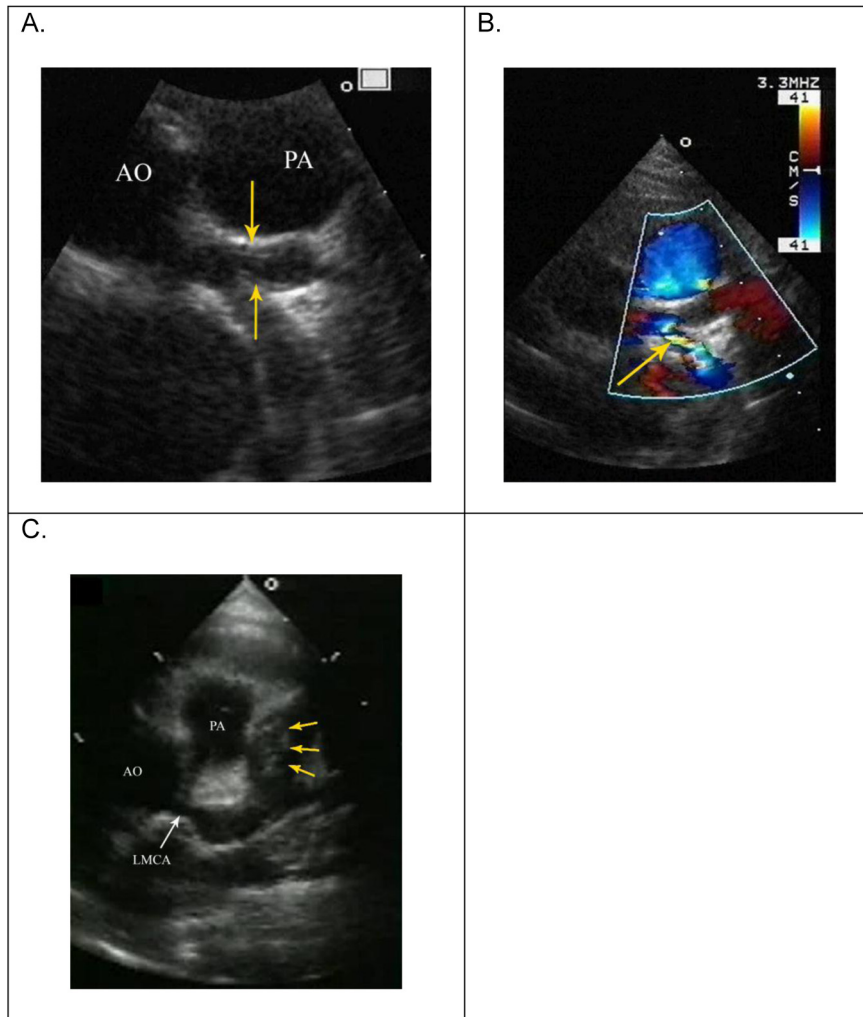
Thickening of the coronary artery luminal wall within an aneurysmal coronary artery in a patient with Kawasaki disease, presumably due to myointimal cellular proliferation (A). Turbulent color Doppler signal in the left main circumflex coronary artery, even with color Nyquist limit of 41 cm/sec, suggests stenosis (B). A severely dilated left anterior descending coronary artery with thrombus formation in the midsegment (C). AO, Aorta.
